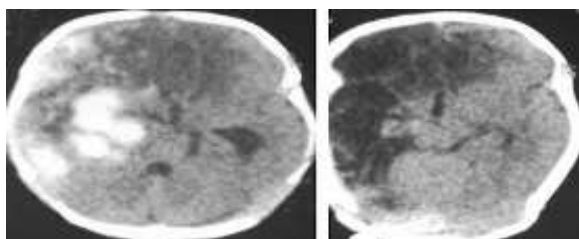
MRI of a 2-year-old child with hemorrhagic stroke due to hemophilia [14]
